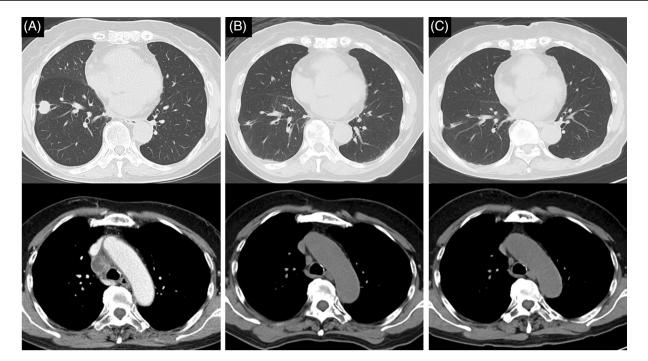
Chest computed tomography findings showing a tumour in the right lower lobe and enlarged lymph nodes in the mediastinum at (A) admission and (B) nine and (C) 18 months after treatment.
